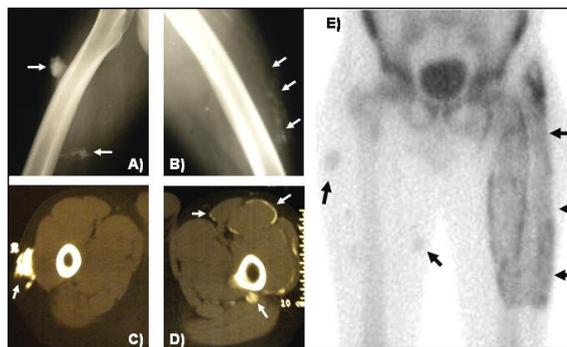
Identification of calcinosis in left and right thighs with different imaging methods. Lateral radiographs of the right (A) and left (B) thighs show deep and diffuse calcinosis respectively. Computed tomography of the thighs showing tumoral calcinosis in right leg (C) and diffuse calcifications along fascial planes of the muscles in left leg (D). Bone scan (E) shows increased soft-tissue uptake of the radiotracer with deep deposits of calcium in the right thigh and extensive subcutaneous calcinosis that spreads over almost the entire left thigh.
